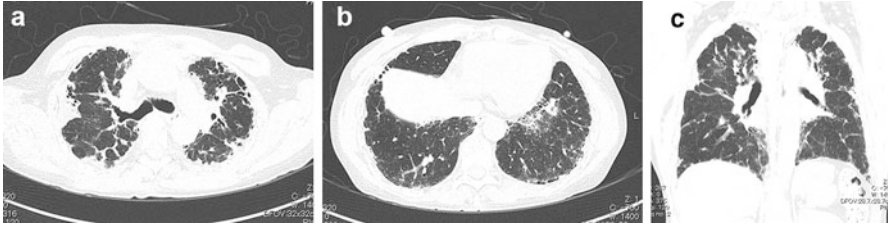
Chronic hypersensitivity pneumonitis (CHP). (a) High-resolution computed tomography (HRCT) at the pulmonary apex shows multiple subpleural areas of atelectatic induration abutting the chest wall. Small cysts are also identified. (b) HRCT of the lower lung shows interstitial pneumonia with a UIP pattern. (c) Coronal reformatted image shows that reticular opacity is confined to subpleural regions
